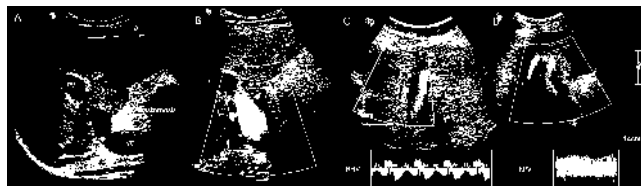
Doppler ultrasound examination revealing normal portal flow patterns in both portal (C) and hepatic (D) veins.
